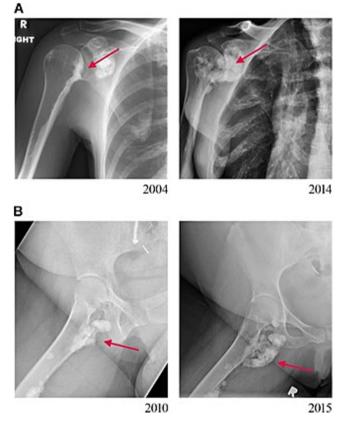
Slow progression of melorheostosis. (A) Anterior-posterior radiograph of the shoulder shows increase in melorheostosis after 10 yr. (B) Lateral radiograph of hip shows increased in size and density of exostosis. From Jha et al.,²³ used by permission.
